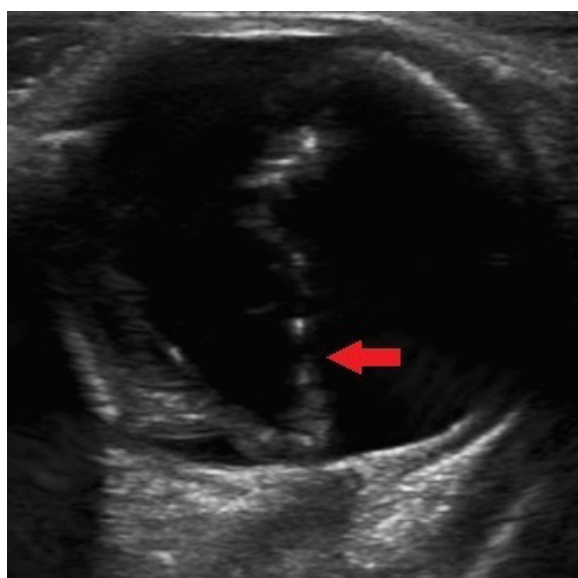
B scan ultrasonography of left eye reveals proliferative vitreoretinopathy with V-shaped retinal flap having apex at optic disc consistent with retinal detachment (red arrow)
